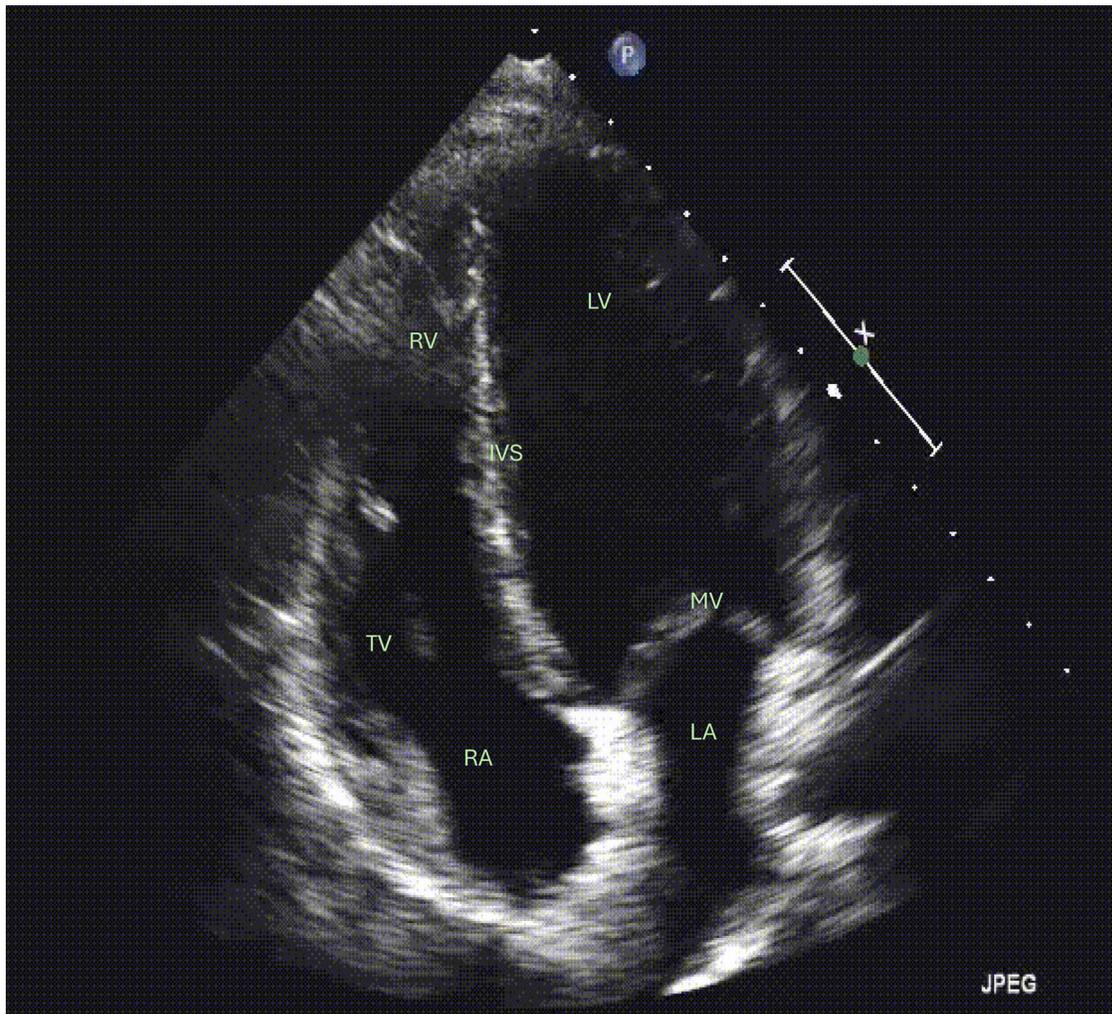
Labelled view of apical 4-chamber view⁵.
